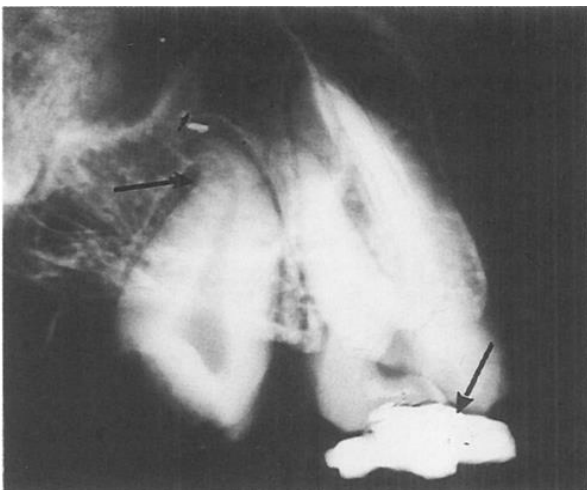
Radiograph of a portion of the upper right maxilla found showing a second molar and a third molar root
